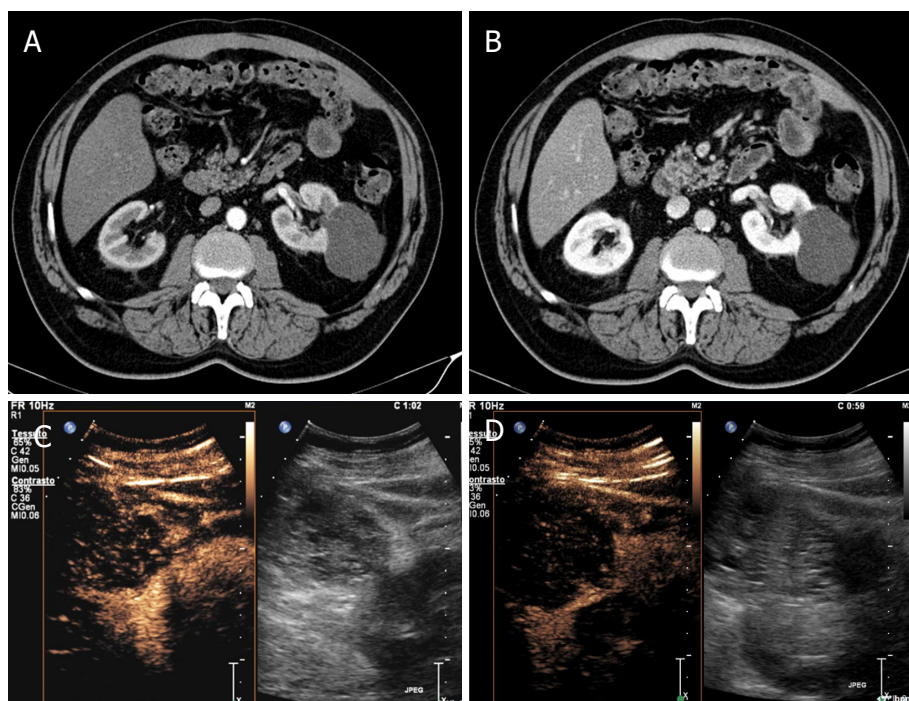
Indeterminate renal lesions at CT study. Contrast CT shows in the left kidney voluminous, partially exophytic, hypodense lesion with irregular margins and without enhancement in phases arterial (A) and venous phase (B). Greyscale and contrast-enhanced sonography (C-D) shows a lesion with mixed echo structure and after microbubble injection shows multiple vascularized septa (Bosniak 4)
